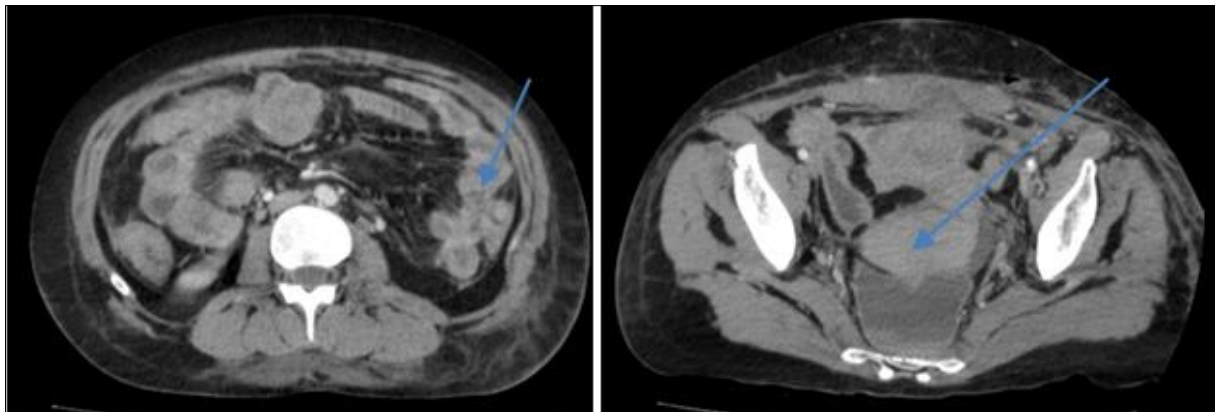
Axial section CT scan: reactive parietal thickening of the bowel and colon with a pelvic hematoma
